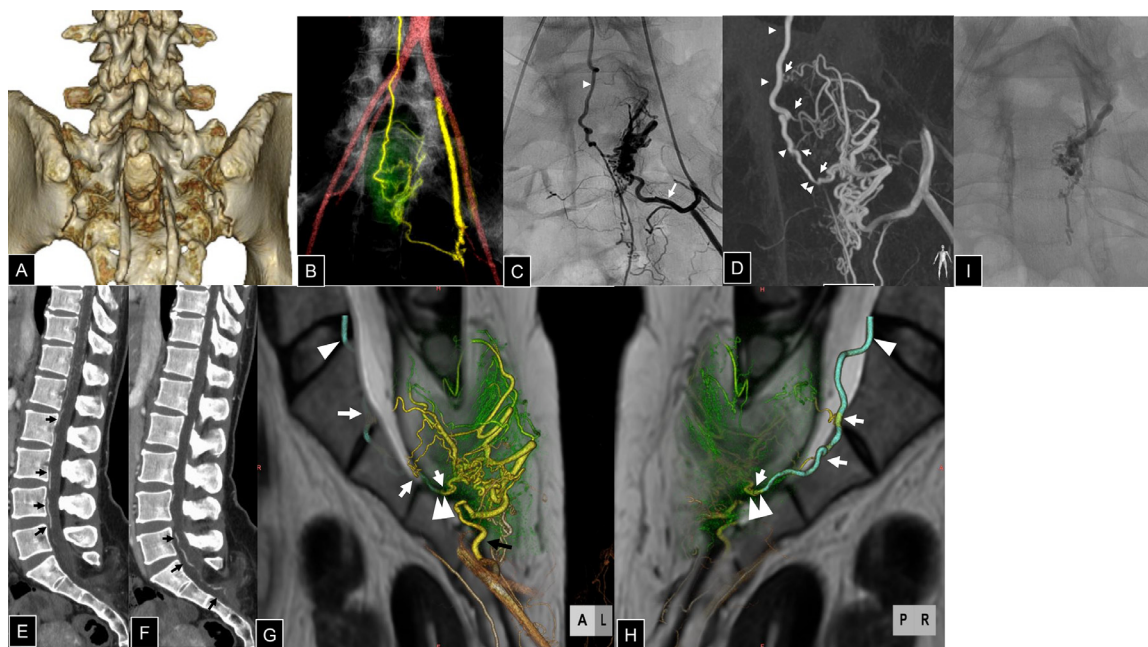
(A) 3D reconstructed image of bone CT reveals spinal bifida at sacrum. (B) Contrast-enhanced CT shows the third sacral artery branching from left lateral sacral artery was the feeder involved in the arteriovenous fistula. (C) Anterior-posterior view of the angiography of the third sacral artery (arrow) and the draining vein (arrowhead). (D) 3D rotational angiography of the third sacral artery reveals origin of the draining veins (double arrowheads) and developed and ascended ventral to the spinal cord (arrowheads). Multiple fistulas are shown in arrows. (E, F) Lateral view of contrast-enhanced CT shows draining vein ascending ventral to the spinal cord. (black arrows). (G) Fusion image of sagittal MRI T2WI and 3D rotational angiography seen from left anterior oblique. Black arrow indicates the main feeder from third sacral artery. The draining vein is shown with arrowheads and its origin is shown with double arrowheads. Shunt points are labeled with arrows. (H) Fusion image of sagittal MRI T2WI and 3D rotational angiography seen from right posterior oblique. The draining vein is shown with arrowheads and its origin is shown with double arrowheads. Shunt points are labeled with arrows. I: Embolization from the third sacral artery showing the feeder is partially embolized by 0.33 ml of 20% N-butyl-cyanoacrylate.
